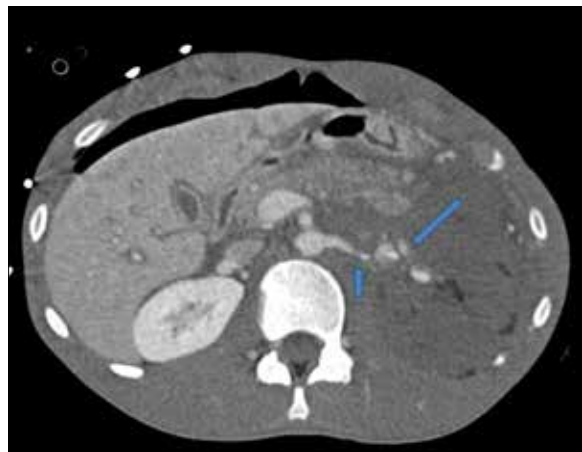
Contrast-enhanced CT scan of the abdomen demonstrating abrupt termination of the left renal artery (short arrow), with adjacent contrast blush/extravasation (long arrow), suggesting renal arterial laceration. Devascularized left kidney is also noted. The right parenchyma is normally enhanced.
